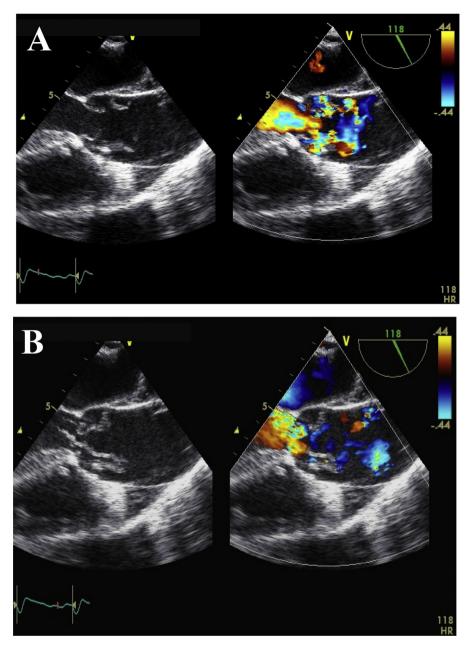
Transesophageal echocardiography: (A) aortic root and left ventricular outflow tract in systole, showing dissection flaps, (B) aortic valve in diastole, showing the intimal flap prolapsing across the aortic valve into the LVOT with wide-open aortic regurgitation.
